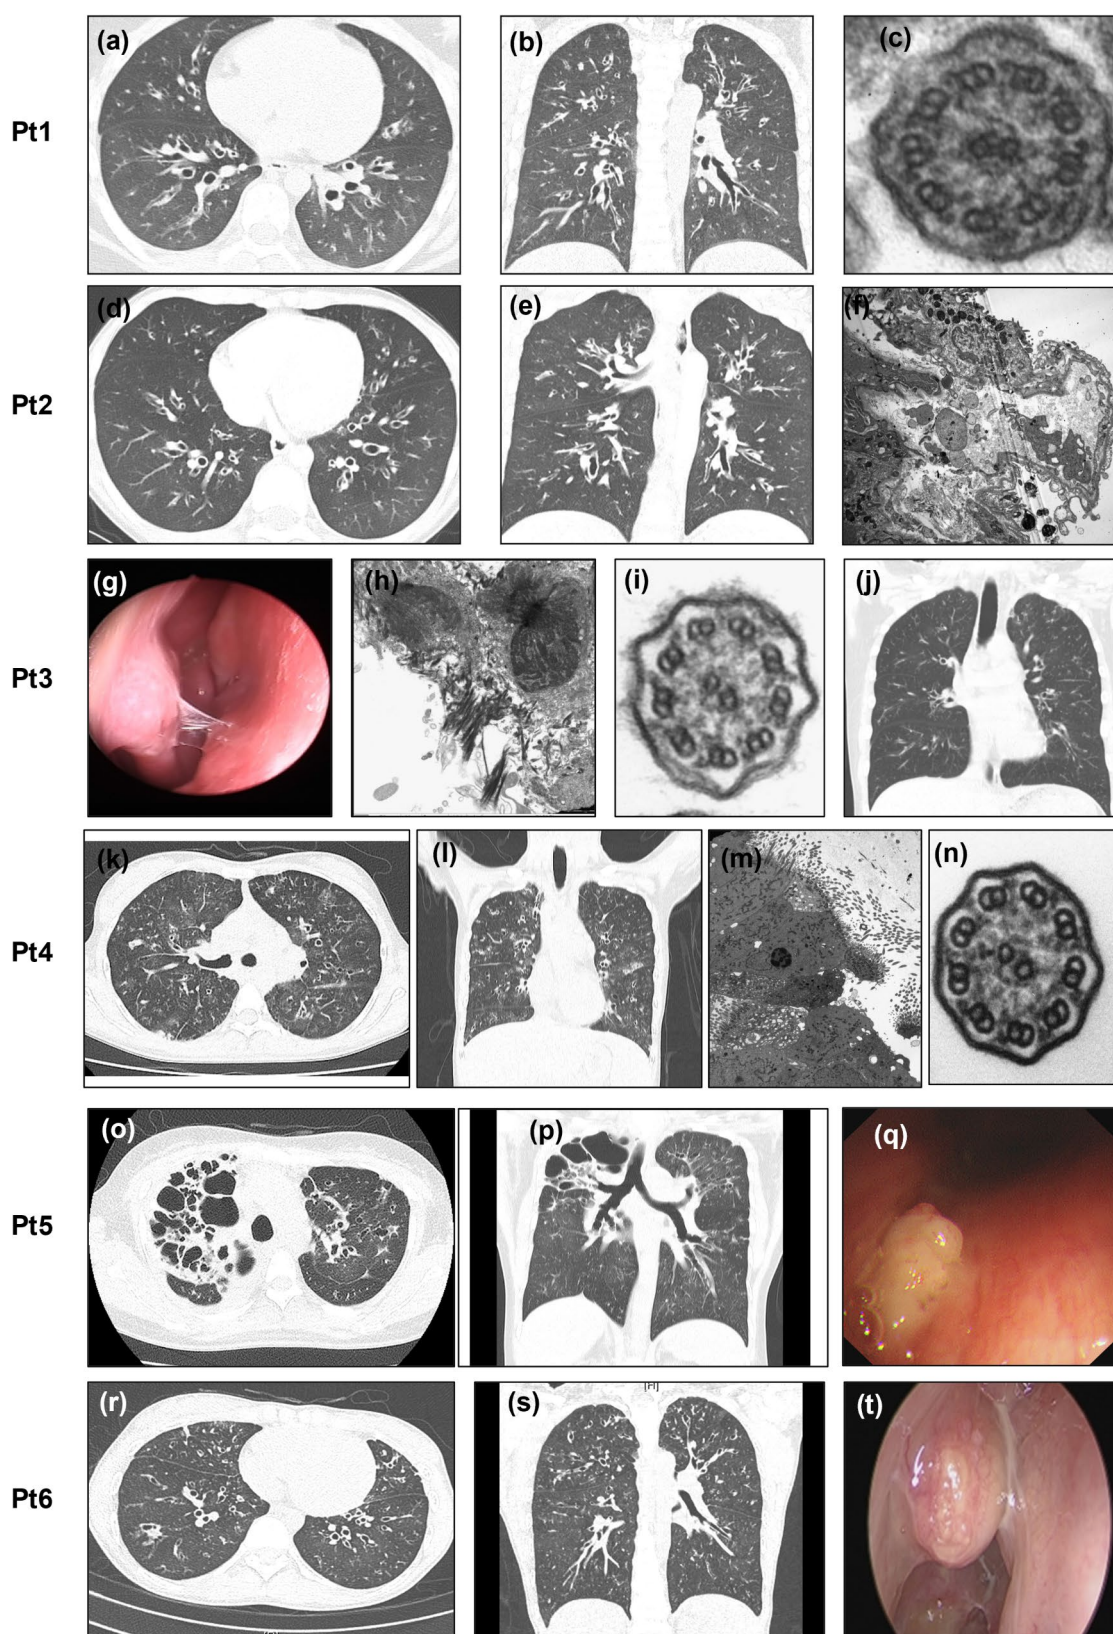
Clinical manifestations of patients with bronchiectasis associated with WFDC2 mutations. Patient 1: (a, b) lung CT scans, (c) TEM image of microtubules in the bronchial cilia; Patient 2: (d, e) lung CT scans, (f) TEM image of damaged nasal cilia; Patient 3: (g) nasal polyp, (h, i) TEM images of the nasal cilia and microtubules, (j) lung CT scan; Patient 4: (k, l) lung CT scans, (m, n) TEM image of bronchial cilia and microtubules; Patient 5: (o, p) lung CT scans, (q) bronchial polyp; Patient 6: (r, s) lung CT scans, (t) bronchial polyp
